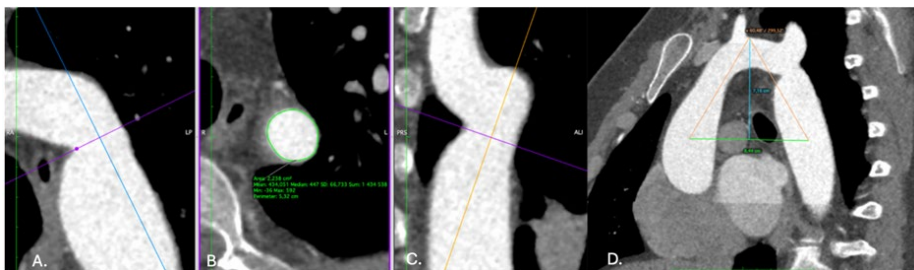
CT scan measurements. A and C - oblique angulations orthogonal to the vessel's longitudinal axis for mean diameter calculations (B). D – aortic arch height, width, and angulation measurements.
